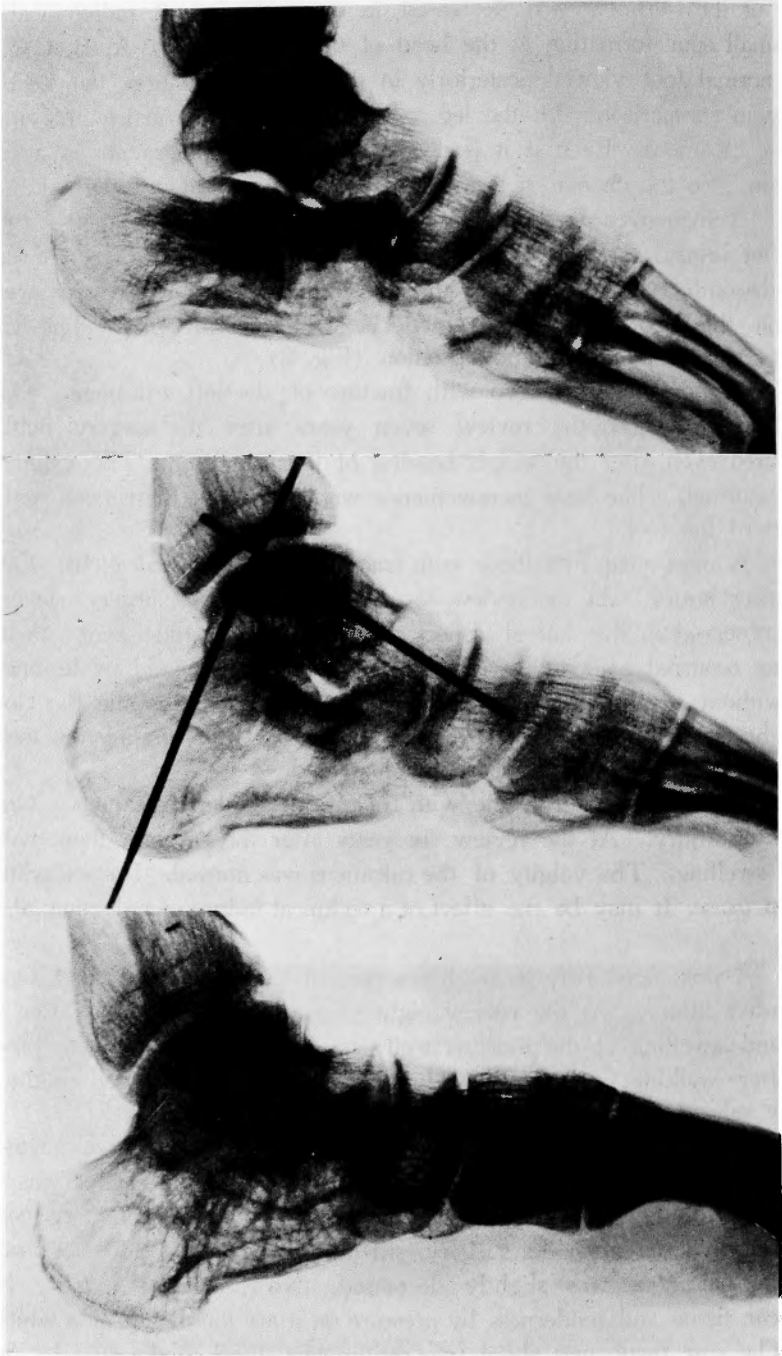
Case 2. Lateral roentgenograms of the right foot. Above: after injury. Middle: after surgery. Below: eight years after the surgery. The foot is compatible with excessive work.
